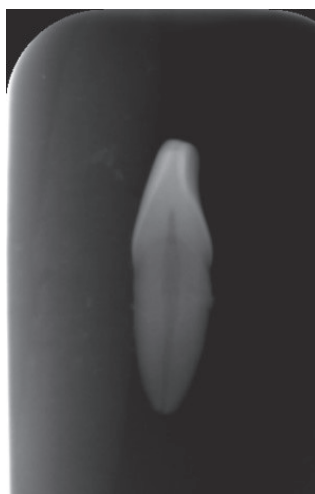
A digital radiographic image (phosphor plate image) of tooth 41 taken with a mesiodistal orientation.
